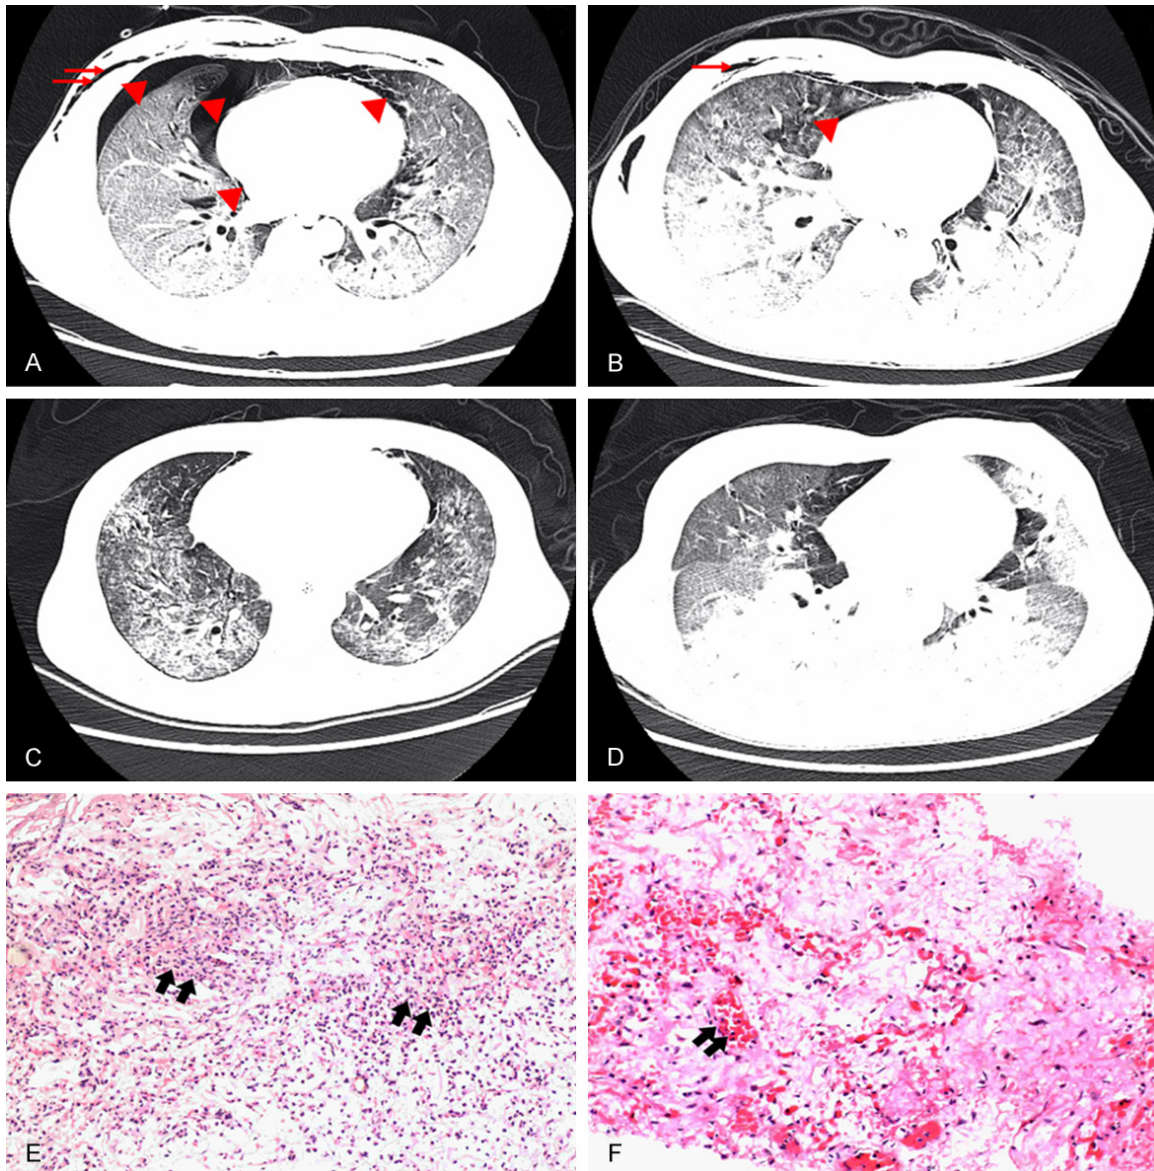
(A-D) CT scan results of case 1 and case 2 before (A, B) and after (C, D) ECMO. The triangles indicate pneumothorax and the arrow indicate subcutaneous emphysema. (E, F) The pathological findings of lung tissues from case 3 revealed acute lung injury and inflammation and fibrosis; (E) The interstitial spaces were filled with neutrophils, revealing severe interstitial inflammation; (F) The intraalveolar spaces were filled with red blood cells and white blood cells, indicating pulmonary alveolitis.
